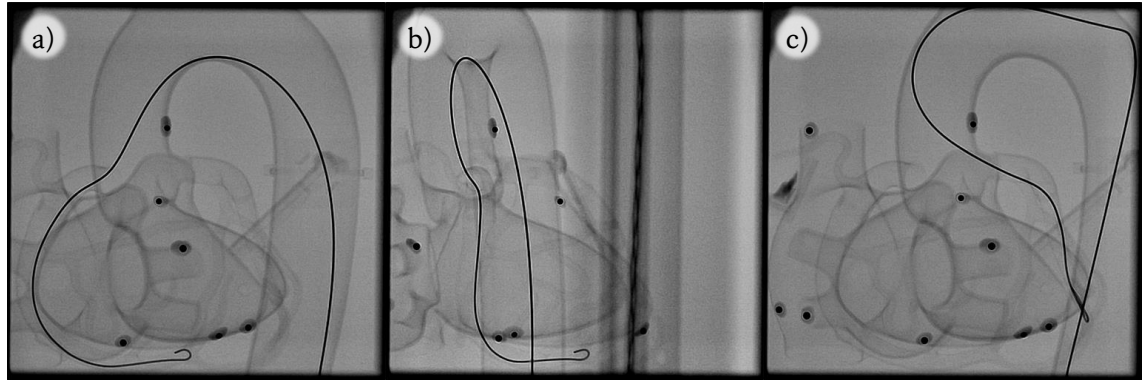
a) A guidewire is inserted into the RCA of the plastic heart via the DAo and imaged with X-ray PA and b) RAO 45° views. c) PA X-ray view of the plastic heart with LAD catheterised via the DAo.
